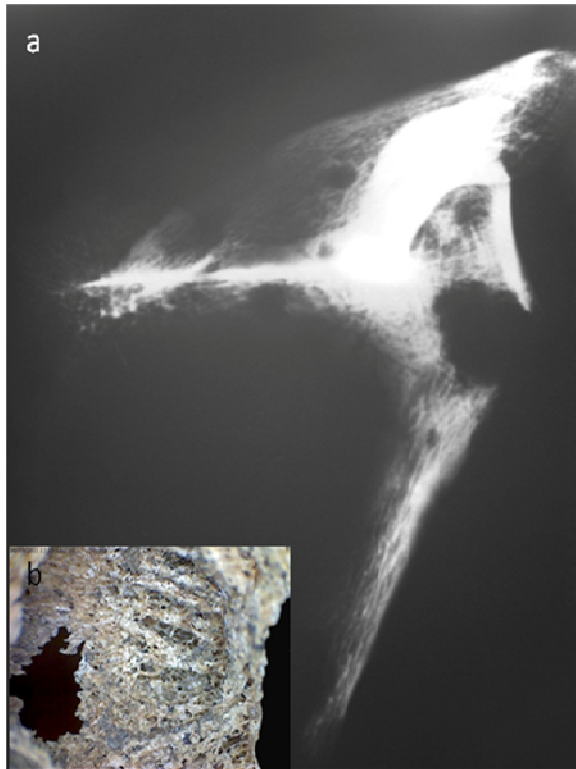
Radiograph of the left scapula (a) showing multiple lytic destructions of the bone with variable shapes and dimensions; (b) detail of the lesion situated inferior to the glenoid surface showing the presence of buttressing bone.
